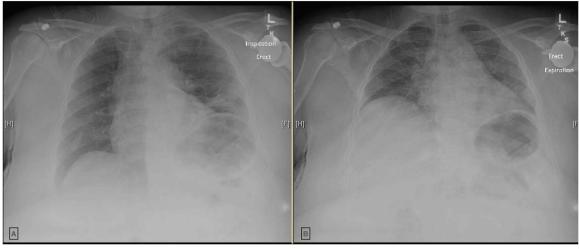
Patient's inspiratory (A) and Expiratory (B) plain x-ray films demonstrating clear right lung, no pneumothorax or pleural effusion. Inspiratory and expiratory exams show excellent right hemidiaphragm excursion. No definite left hemidiaphragm excursion. Per radiology report, "possible phrenic nerve injury or diaphragm paralysis can be further evaluated with fluoroscopic sniff test clinical discretion."
